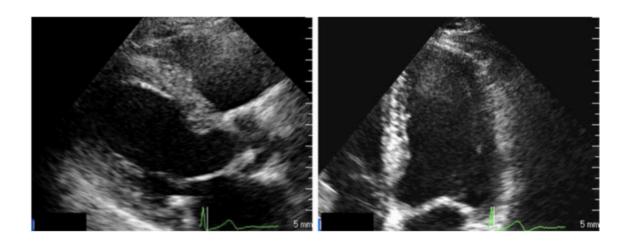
Long parasternal axis (left) and four chamber of concentric LVH. (29)
